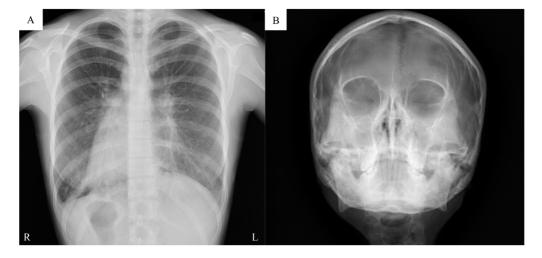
Chest and sinus cardiograph of the Patient 1.(A) Chest radiograph at the time of admission reveals situs inversus. (B) The sinus radiograph reveals bilateral maxillary sinusitis.
